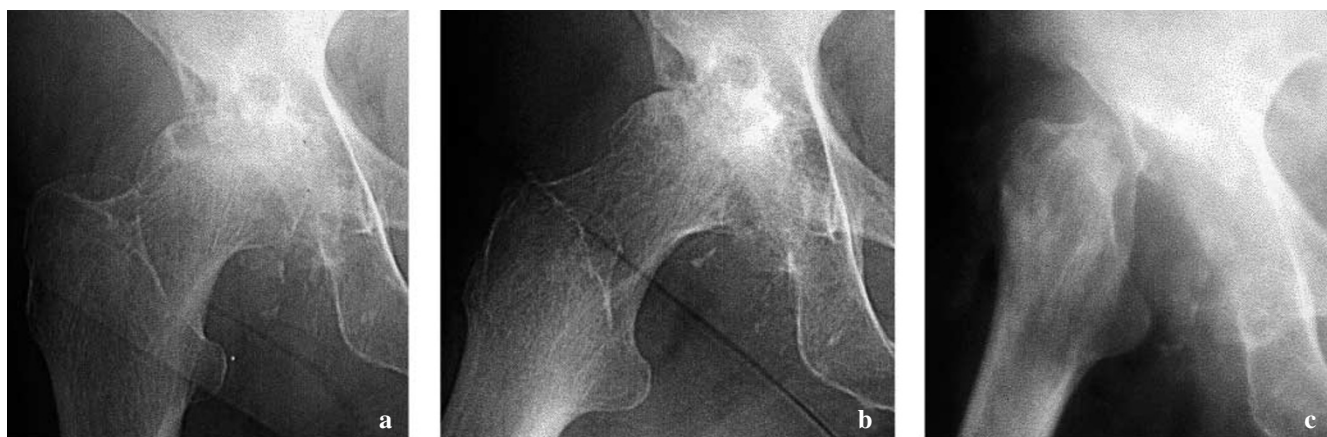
a, b Anteroposterior radiographs of the right hip in neutral position (a) and in abduction and external rotation (b) showed the complete disappearance of the joint space and osteolytic cystic-like lesions of the upper part of the femoral head and the outer third of the acetabulum. c Three months later, a complete destruction of the hip joint with proximal migration of the femoral diaphysis was observed
